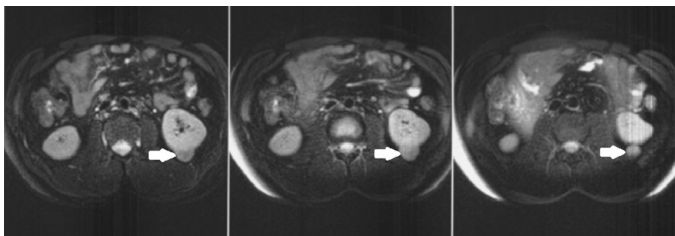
Magnetic resonance imaging image of the 4 cm tumoral lesion of the patient at the inferior pole of the left kidney
